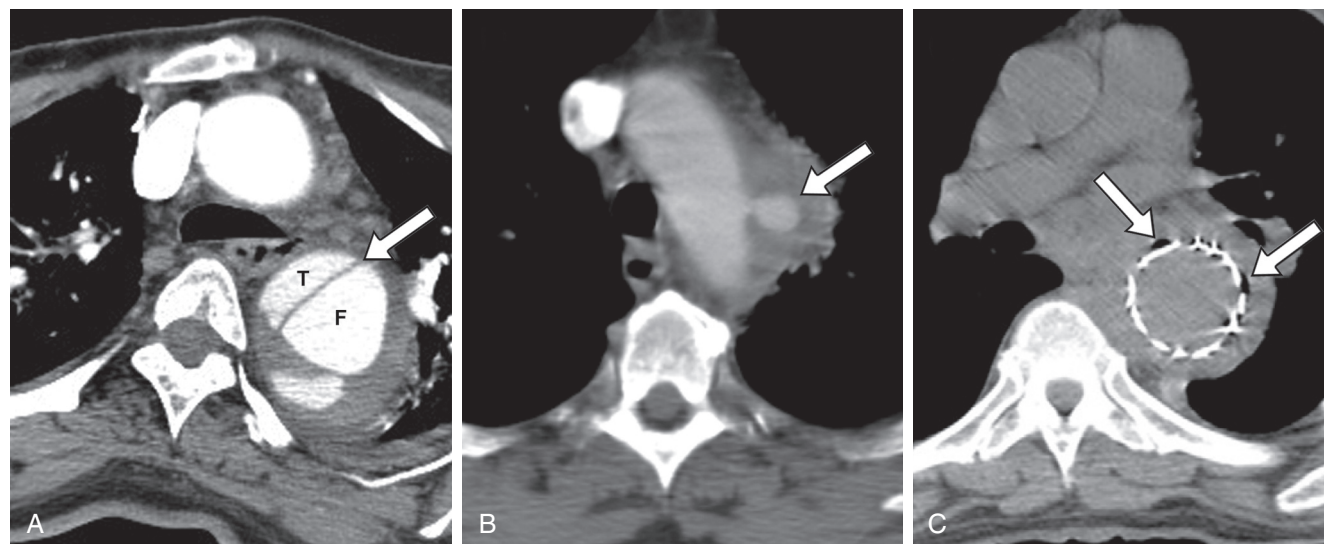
■ Computed tomography scans showing key diagnostic findings. A, Chronic distal aortic dissection; the dividing septum is relatively straight (arrow), and the true (T) and false (F) lumens are indicated. B, Mycotic aneurysm, which is sacular in shape (arrow). C, Infection of an endograft; gas bubbles, indicated by arrows, may be seen near the endograft. (Used with permission of Baylor College of Medicine.)
